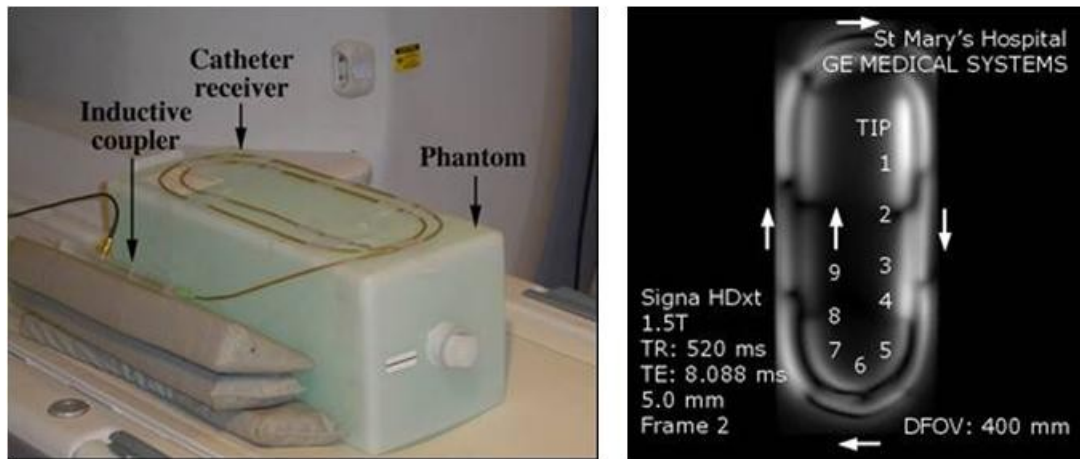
Catheter coil imaging, with (l) experimental arrangement and (r) coronal MR image. The MR image labels correspond to the labels in Fig. 4.4.10 (b) above.
